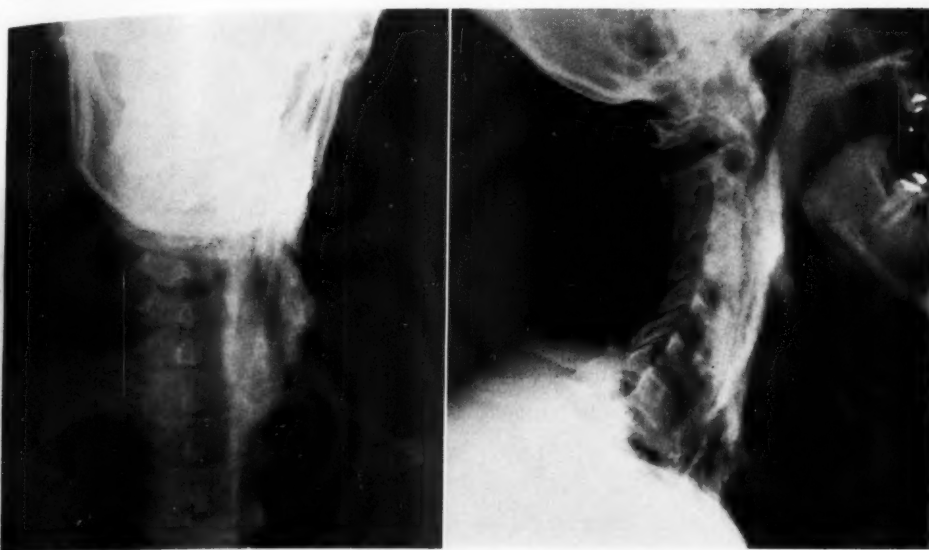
Roentgenograms of the neck, Jan. 15, 1957, showing the conglomerate calcified mass in the left neck. Note that the shadow extends from the base of the skull into the left superior mediastinum.
